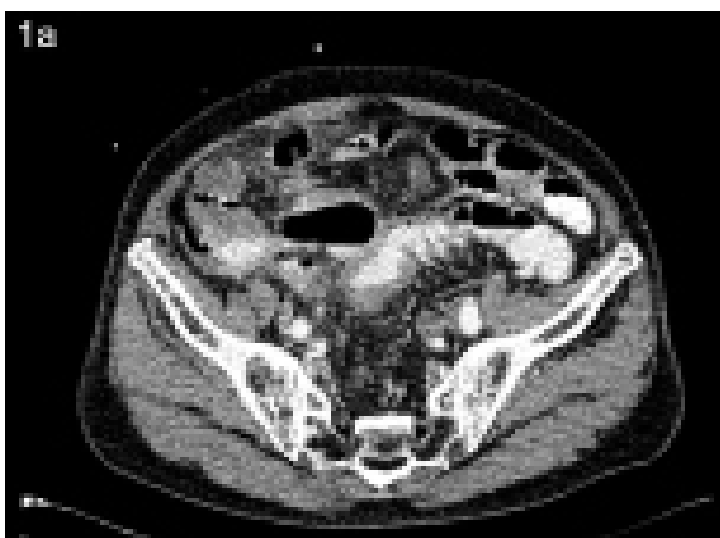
Contrast enhanced computed tomography showing diffuse thickening of the rectosigmoid colon
